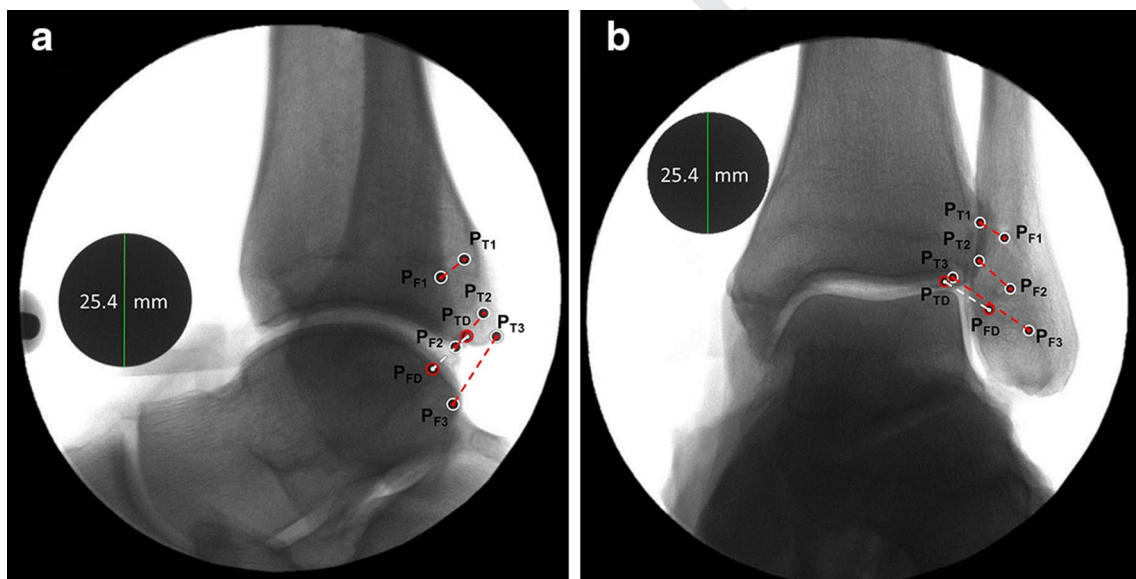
Representative a lateral and b mortise radiographic views demonstrating the posterior–inferior tibiofibular ligament (PITFL) attachment sites including the superficial and deep components. The proximal (P_{T1}/P_{F1}) and distal (P_{T3}/P_{F3}) margins of the superficial
